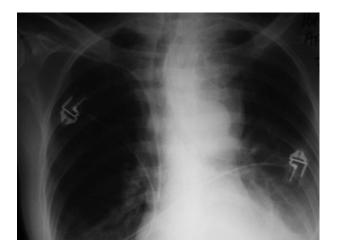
Case 3: chest X-ray showing a mediastinal mass, with significant tracheal deviation to the right.
